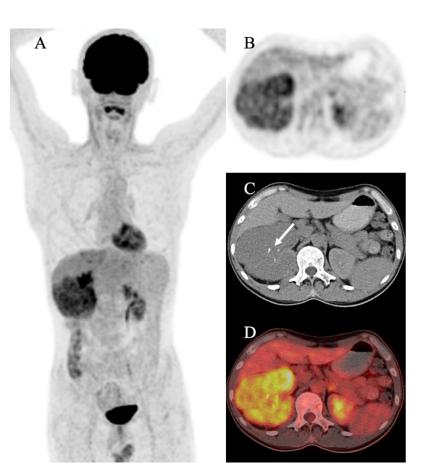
A 48-year-old man with a history of radio-chemotherapy of adenoid cystic carcinoma (ACC) of the nasopharynx eight years ago, fluorine-18-fluorodeoxyglucose positron emission tomography/computed tomography (¹⁶F-FDG PET/CT) was performed for follow-up. Fluorine-18-FDG PET/CT maximum-intensity-projection (MIP) (A) image revealed a mass with moderate ¹⁸F-FDG uptake in the right kidney. Transaxial PET (B), non-contrast-enhanced CT transaxial (C), and PET/CT fusion (D) images showed a lobulated mass with moderate and heterogeneous ¹⁸F-FDG uptake in the right kidney, and several calcified nodules were observed in the mass (arrow). The ACC metastasis of right kidney was suspicious. Subsequently, right nephrectomy was performed. Renal metastasis from ACC was confirmed pathologically, and the Ki-67 was 25% to 35%. Adenoid cystic carcinoma is an uncommon malignant tumor arising mainly from secretory glands, most commonly the major and minor salivary glands of the oral and maxillofacial region, whereas it rarely occurs in the nasopharyngeal [1, 2]. Renal metastases from ACC of nasopharynx are extremely rare and reports of specific renal involvement on ¹⁸F-FDG PET/CT have not been extensively found until now [3-6]. As in the above cases, the features of renal metastases from ACC are slightly well-marginated lower-density mass with low-moderate radioactive concentration on ¹⁸F-FDG PET/CT. Based on autopsy series, the incidence rate of renal metastasis ranges from 3% to 15%, lung, breast, gastric and colon cancer, and melanoma being the most frequent tumors described [7]. Renal metastases mainly present as solid or cystic masses and hemorrhagic or diffuse lesions [7], and are generally small, multiple, bilateral, wedge-shaped, with less exogenous growth and generally located in the renal capsule [8], which is frequently misdiagnosed and can mimic radiologically a primary renal tumor. It is often asymptomatic and rarely exhibits hematuria as it is usually located in the reation of the adjacent urothelium
